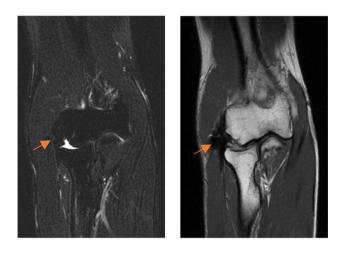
MRI and T1-weighted (respectively) axial frames showing enlargement of the common origin the common origin of the extensor tendons (orange arrow)
